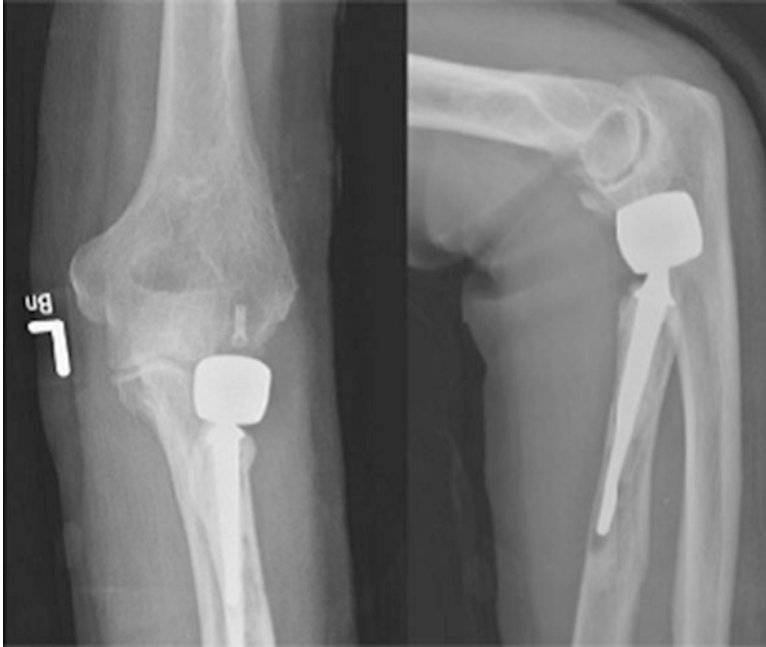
On postoperative X-ray, the MAGNEZIX CS can be identified as mildly radiopaque structure [123]
